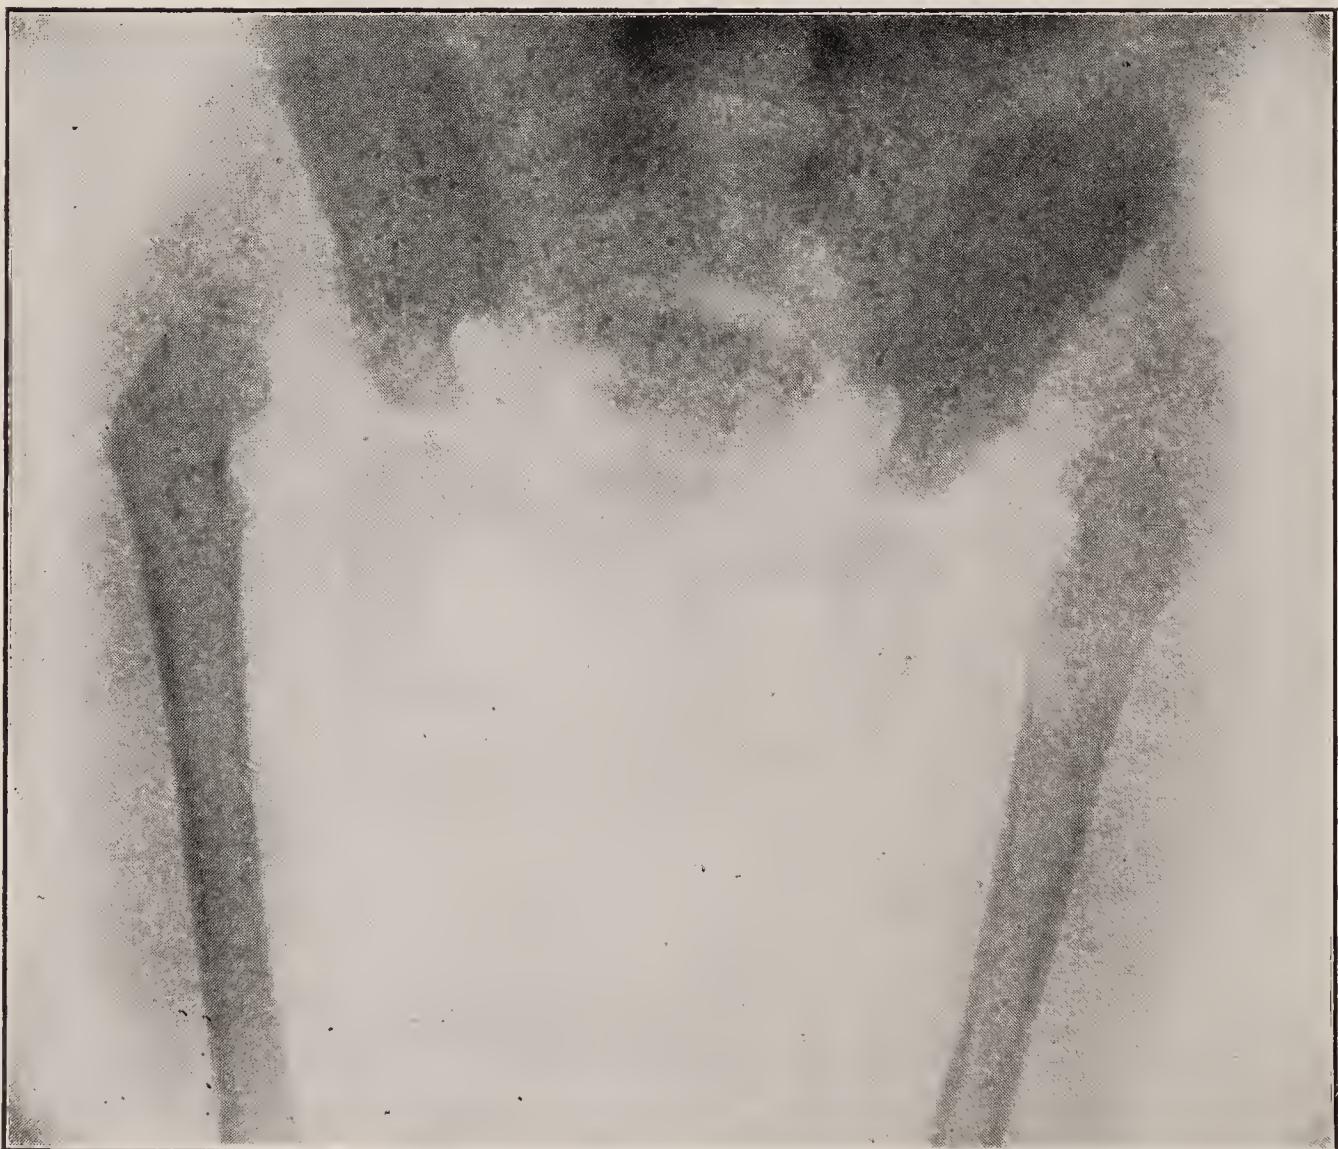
X-ray of double congenital dislocation of the hips.
